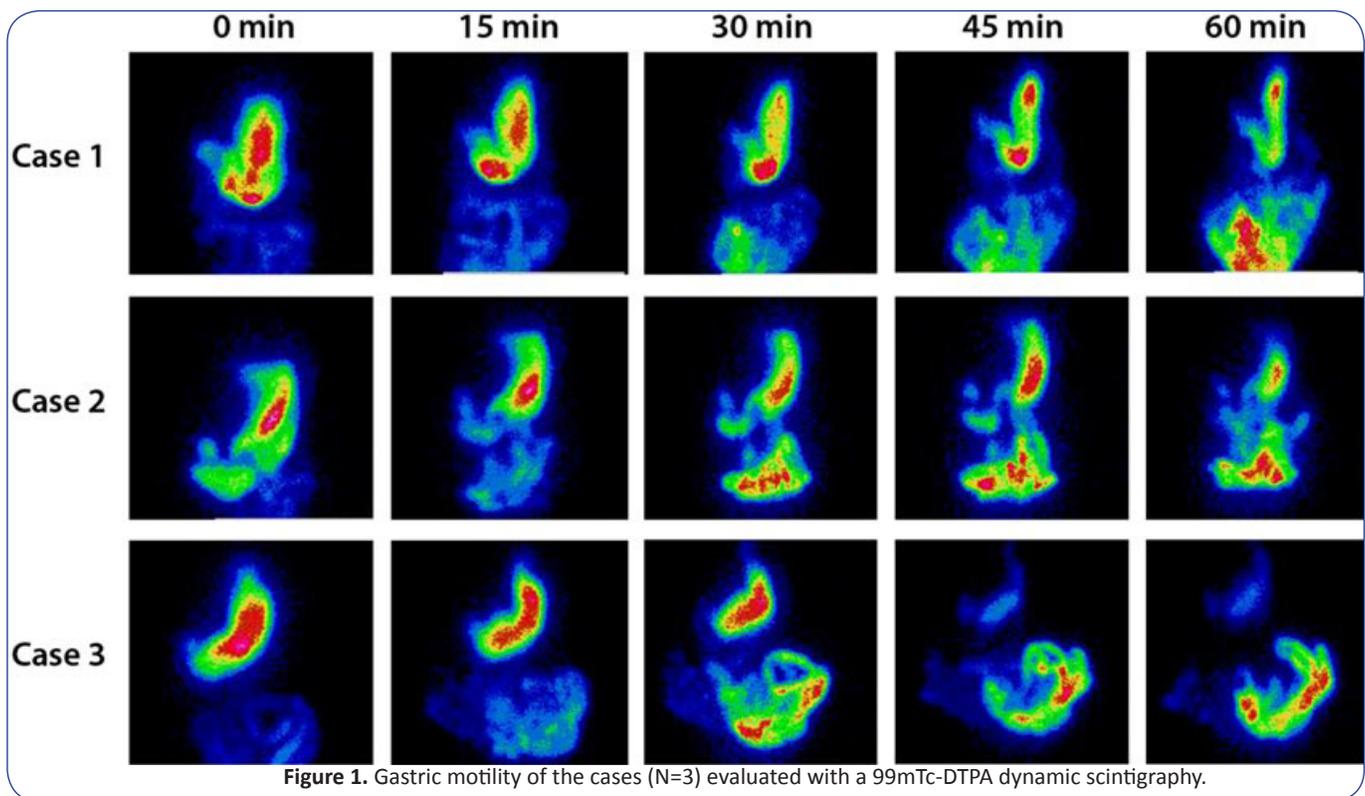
Gastric motility of the cases (N=3) evaluated with a 99mTc-DTPA dynamic scintigraphy.
